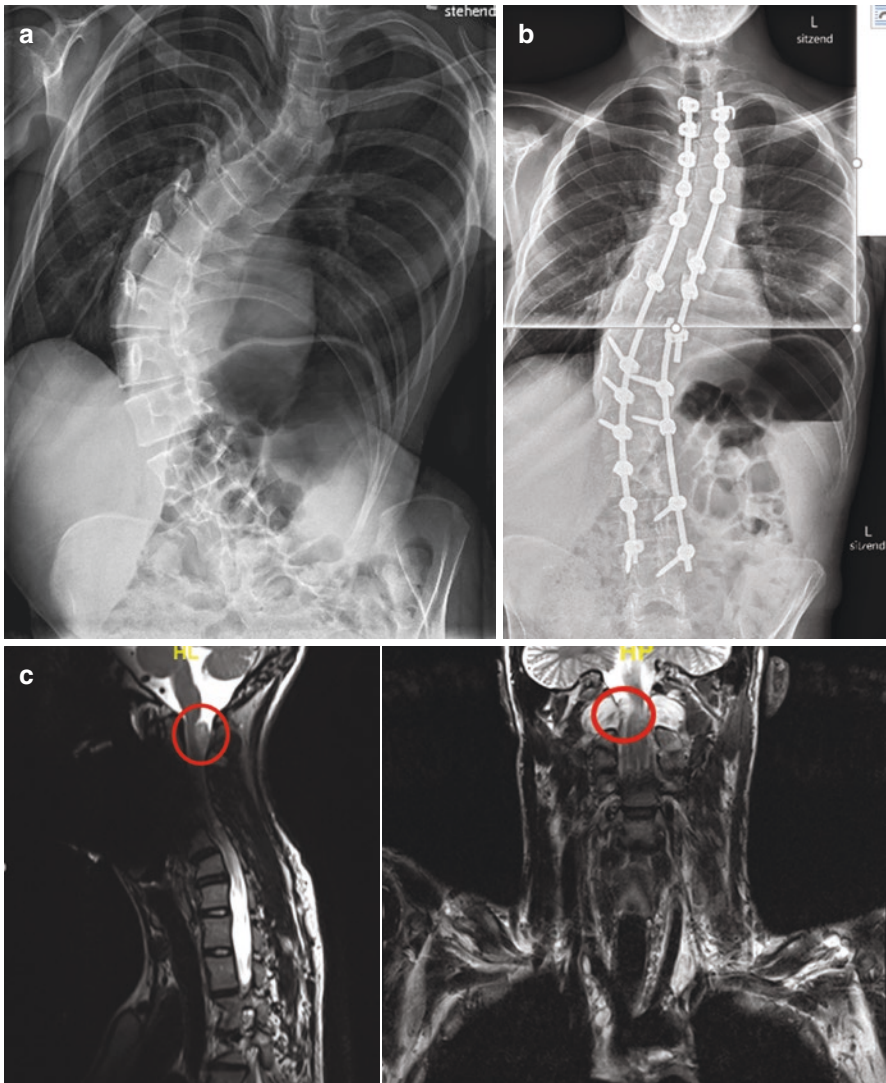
Pre- (a) and post-operative (b) radiographs of a 17 year old patient with NF. The routine preoperative MRI scan (c) showed a neurofibroma compressing the myelon on level C1/C2, which had to be removed by the neurosurgeon before scheduling the patient for operative treatment with posterior spondylodesis for his scoliosis
